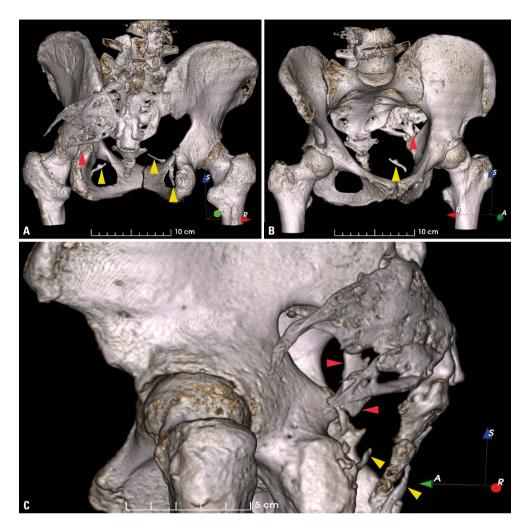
3-D CT reconstruction of the pelvis; A. Posterior view; B. Anterolateral view; C. Lateral view of right pelvis; yellow arrowheads — free bony structures within sacrotuberous ligaments; red arrowheads — third protrusion from the shared sacral platform.
